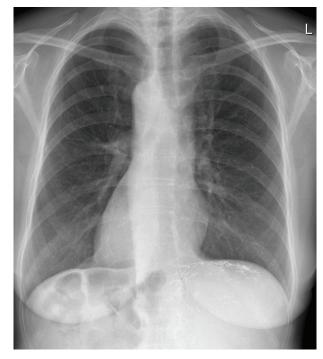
Postoperative chest X-ray showing dextrocardia (thus complete situs inversus)
